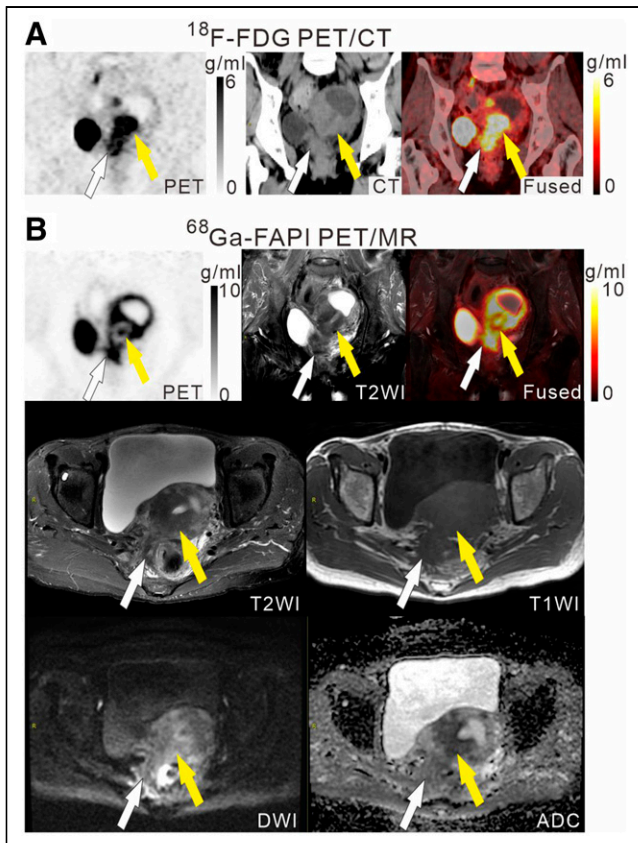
A 45-y-old woman (patient 20) with a surgical history of gastric cancer 4 y previously. ^{18}F -FDG PET/CT (A) showed a mass in the uterus with heterogeneous density and intense ^{18}F -FDG activity (yellow arrows, $\text{SUV}_{\text{max}} = 9.1$), which involved the adjacent rectum (white arrows, $\text{SUV}_{\text{max}} = 5.7$). On ^{68}Ga -FAPI PET/MR (B), there was intense ^{68}Ga -FAPI uptake throughout the uterus ($\text{SUV}_{\text{max}} = 12.7$), which may be physiologic uptake. When signal changes on multiple sequences of MR are interpreted, uterine masses (yellow arrows), disappearance of the fat space, and rectal involvement (white arrows) can be observed and diagnosed as metastases. ADC = apparent diffusion coefficient.
